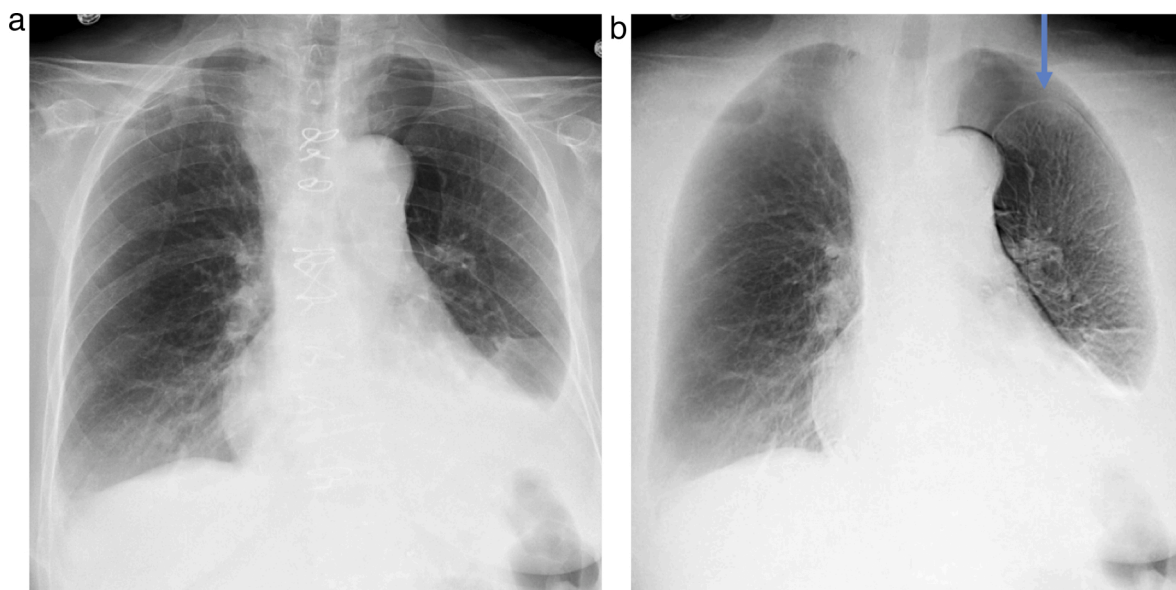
Improved pneumothorax detection in a 45-year-old male following cardiothoracic surgery. Conventional radiograph (a) shows cardiomeastinal silhouette enlargement, mild interstitial pulmonary edema and bilateral pleural effusion. The corresponding soft tissue image (b) shows the hidden left apical pneumothorax (Arrow), which was missed initially on the convention image.
